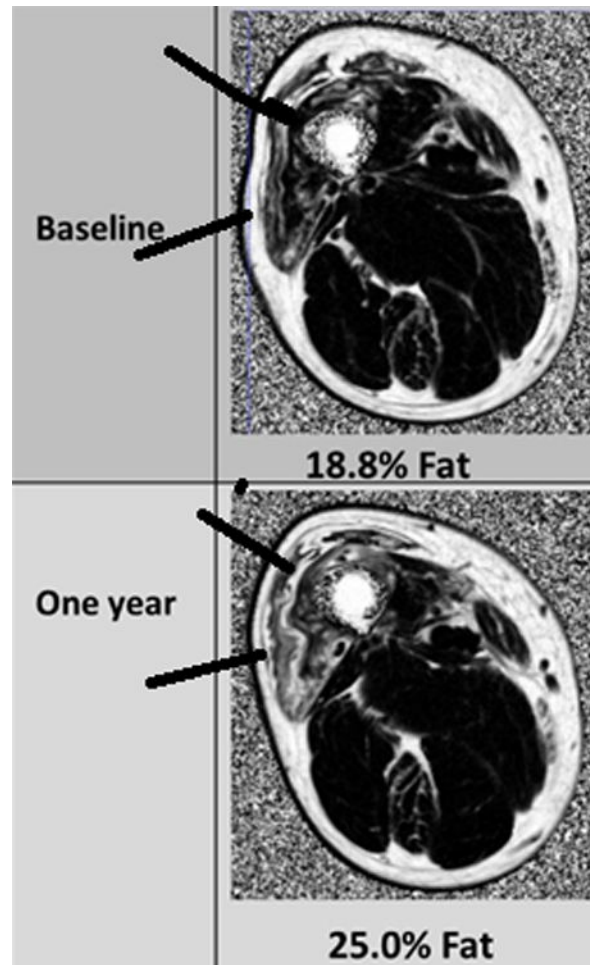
Fat-fraction T1 magnetic resonance imaging (MRI) map in inclusion body myositis. Fat-fraction T1 MRI map of the right thigh in a patient with inclusion body myositis, at baseline and one-year follow-up. An absolute percentage increase of 6.2% in fat fraction was observed.
